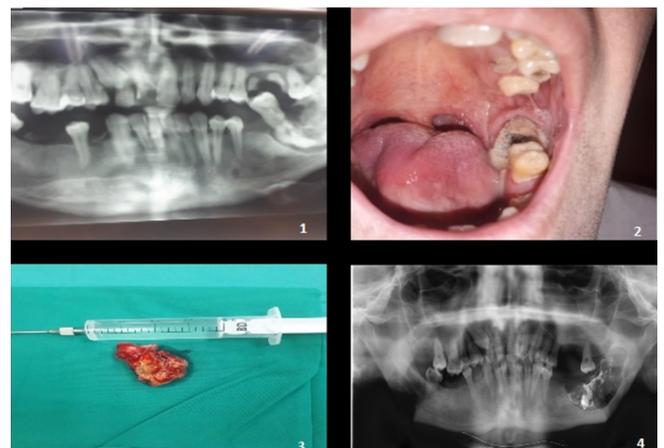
(1)The OPG X-Ray – a visible sequestrum surrounded by an osteolytic halo, (2)The image of the lesion during the intraoral examination (3)The removed bone sequestrum, (4)The OPG X-Ray – the post-surgical image of the loss in the mandible with the presence of iodophor.
